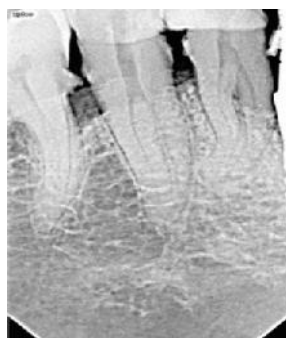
Preoperative radiograph 4th Quadrant showing two rooted First Premolar.
